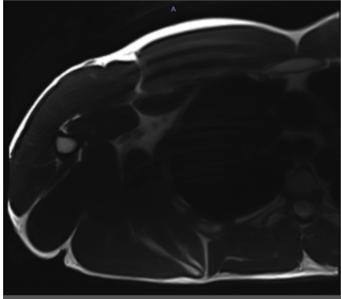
MRI (Magnetic resonance image) of pectoralis muscle after treatment
